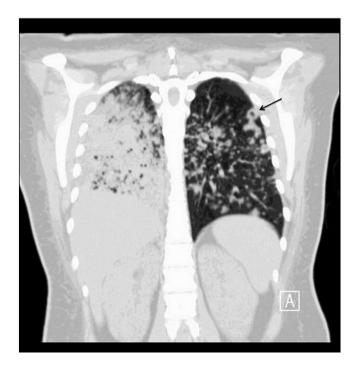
CT chest in coronal view showing right lung consolidation with diffuse ground glass pulmonary nodular infiltrates in both lungs. The arrow highlights a pseudo-cavitation in the left upper lobe.
